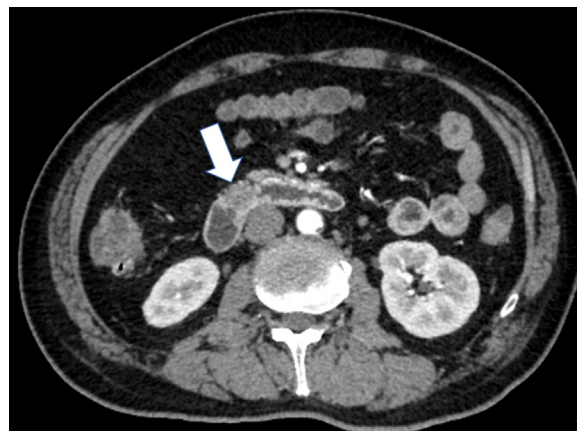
Abdominal computed tomography scan of the duodenal bulb. A low-density nodule, 10 x 4 mm in size and fatty in appearance, is seen in the submucosal layer. No abnormal lymph nodes are seen around the stomach.
